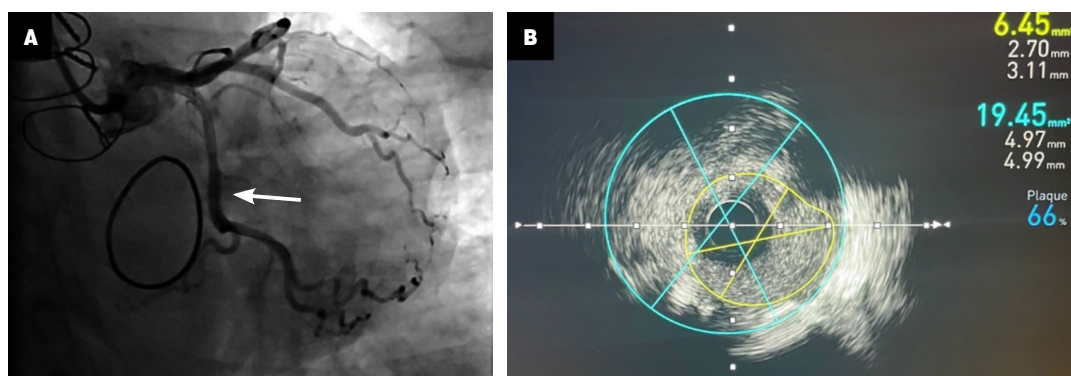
Post-stent implantation imaging. A) Coronary angiography showing correct angiographic stent placement with adequate antegrade flow of the circumflex artery (white arrow). B) Post-stent intravascular ultrasound with good apposition with a luminal area of 6.45 mm².
